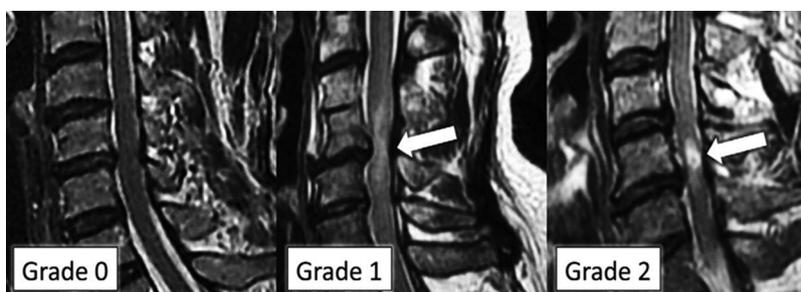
Increased signal intensity (ISI) classification of the spinal cord in T2-weighted MRI. The arrows indicate ISI sites.
